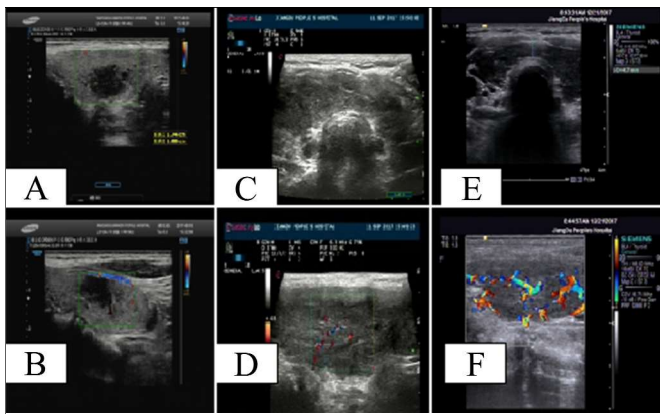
Thyroid color ultrasonography scan demonstrating hypoechoic pattern in the bilateral thyroid (A) and rare blood flow in the hypoechoic areas (B) on August 10, 2017, diffuse hypoechoic pattern (C) and low blood flow (D) on September 11, 2017, and echo disorder, slightly thickened isthmus (E), and rich blood supply (F) on December 21, 2017.
